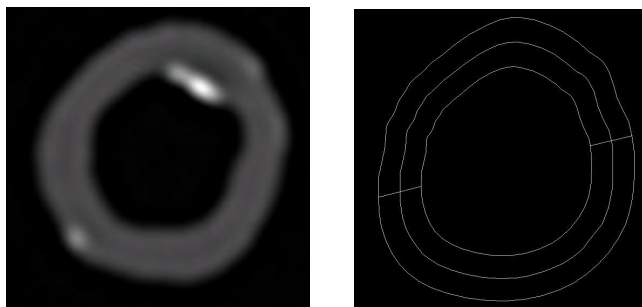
Acquisition and segmentation steps. The left image shows the filtered CT image of a carotid (2.1). The right image shows the results obtained applying the segmentation step and interpolating the points by a BSpline curve (see 2.2).
